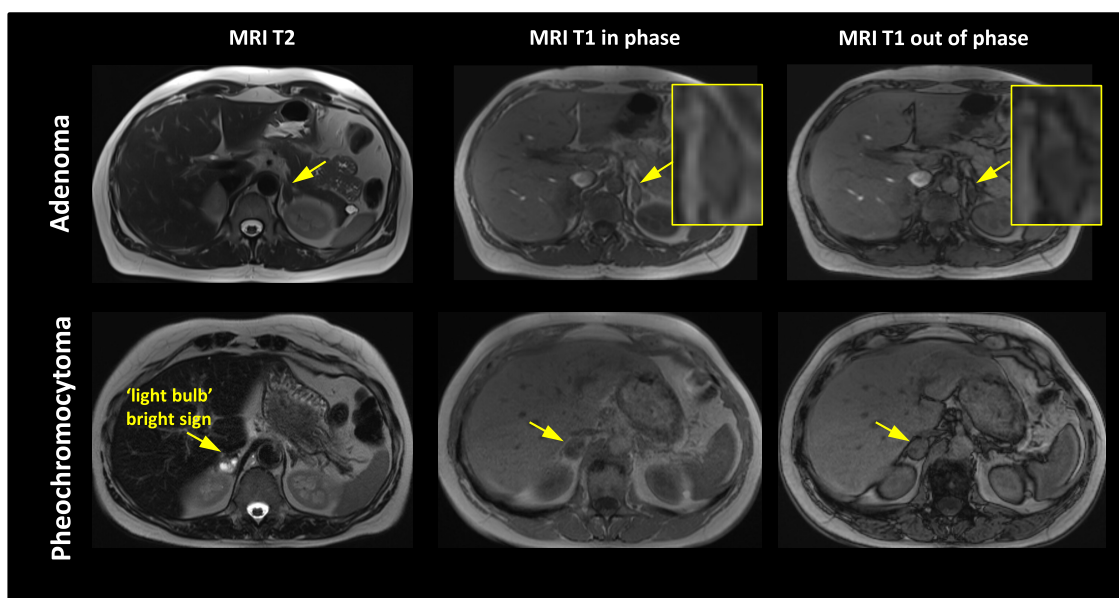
MRI of PCC vs adenoma. MRI images of a patient with left adrenal adenoma with loss of signal (“chemical shift”) in T1 out of phase (upper panels); MRI images of a patient with right PCC with “light bulb” bright sign and no loss of signal in T1 out of phase (lower panels). The adrenal lesions are marked by arrows. Abbreviations: MRI, magnetic resonance imaging.
